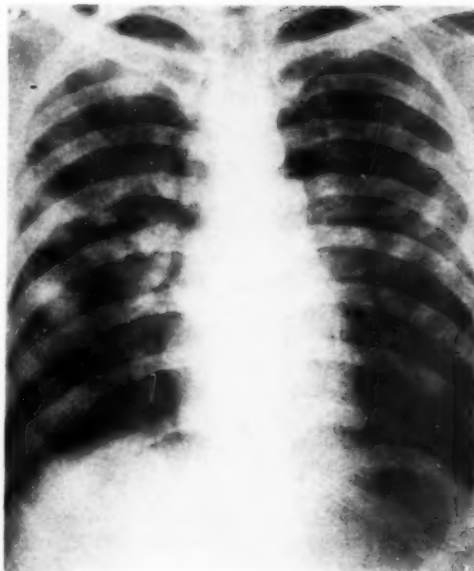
Roentgenogram showing large patchy densities throughout both lung fields.
